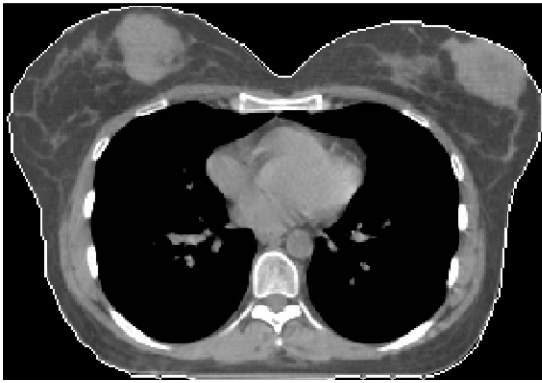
Axial computed tomography images of the patient showing bilateral breast lesions before breathing adapted radiation therapy.
